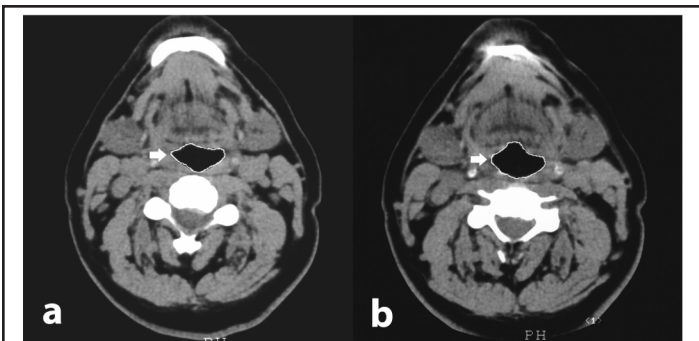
Preoperative computed tomographic scan of the retroglottal area. (a) tidal breathing. (b) Muller maneuver. Arrows point to the retroglottal airway.
